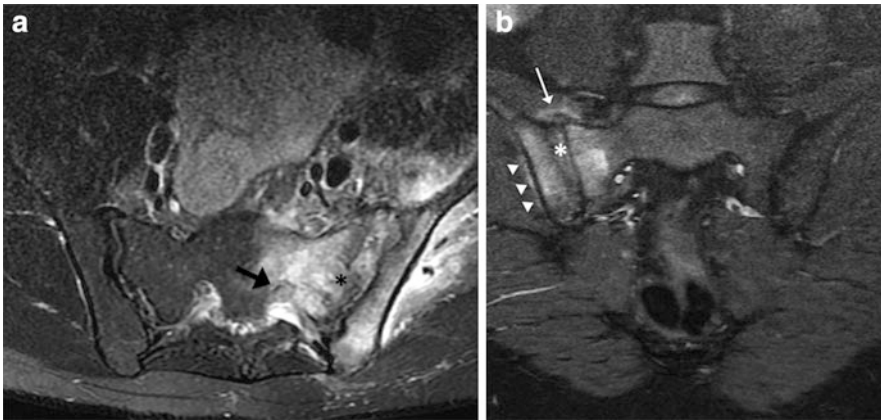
(a) MRI showing infectious sacroiliitis. Axial STIR image shows florid diffuse edema in the sacrum and left ilium as well as in the presacral soft tissues, adjacent gluteal, and iliopsoas muscles. There is widening of the left sacroiliac joint with an effusion, capsular distension, and cortical destruction (asterisk). The left sacral nerve is thickened (arrow), likely reactive due to the surrounding infective change. (b) MRI showing infectious
